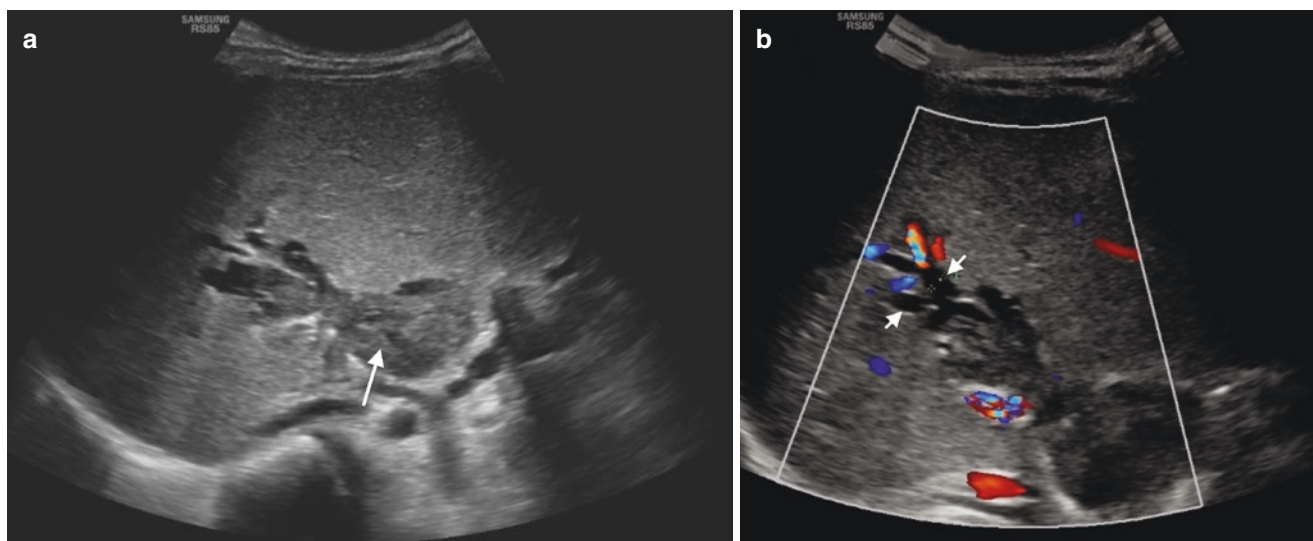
B-mode ultrasound image of a patient with rhabdomyosarcoma relapse demonstrates (a) markedly thickened and expanded bile duct (arrow). (b) Distal intra-hepatic biliary dilatation (arrows)
